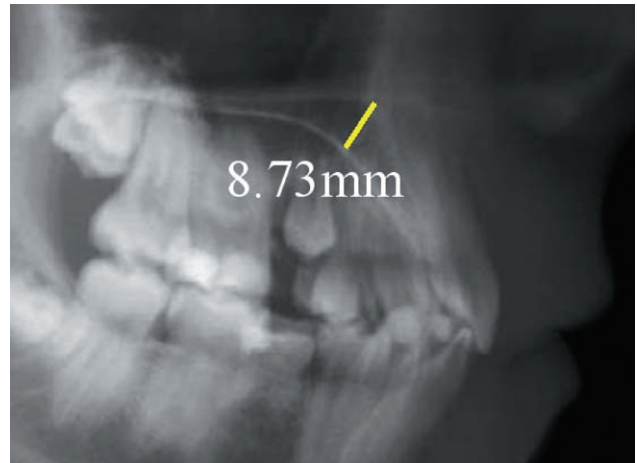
Preoperative assessment of bone on lateral radiographs: vertical bone height was measured along the prospective longitudinal axis of the implant. In this case, 8.73 mm of bone was available at the site of the implant.
